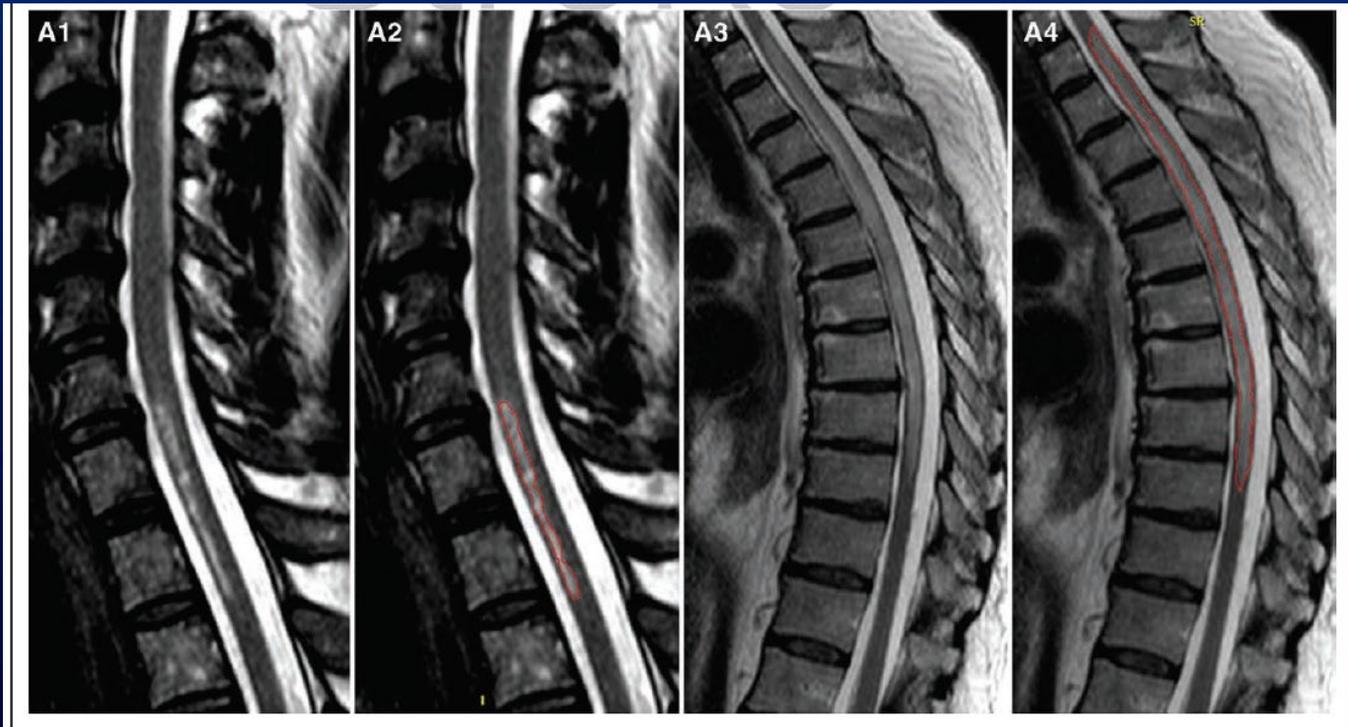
Manual assessment of lesion area on spinal cord magnetic resonance imaging (MRI).
